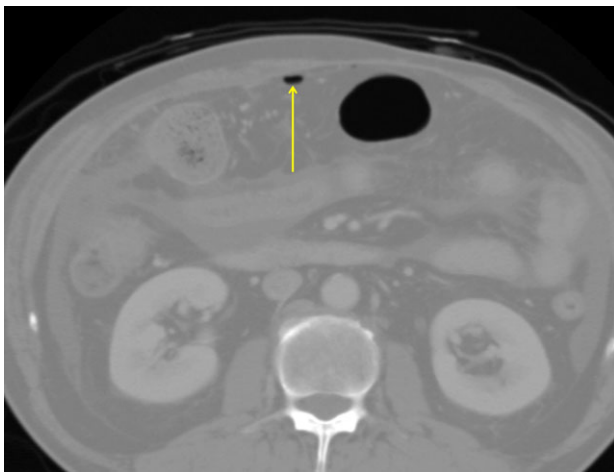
CT imaging findings of intraperitoneal free air (arrow).
